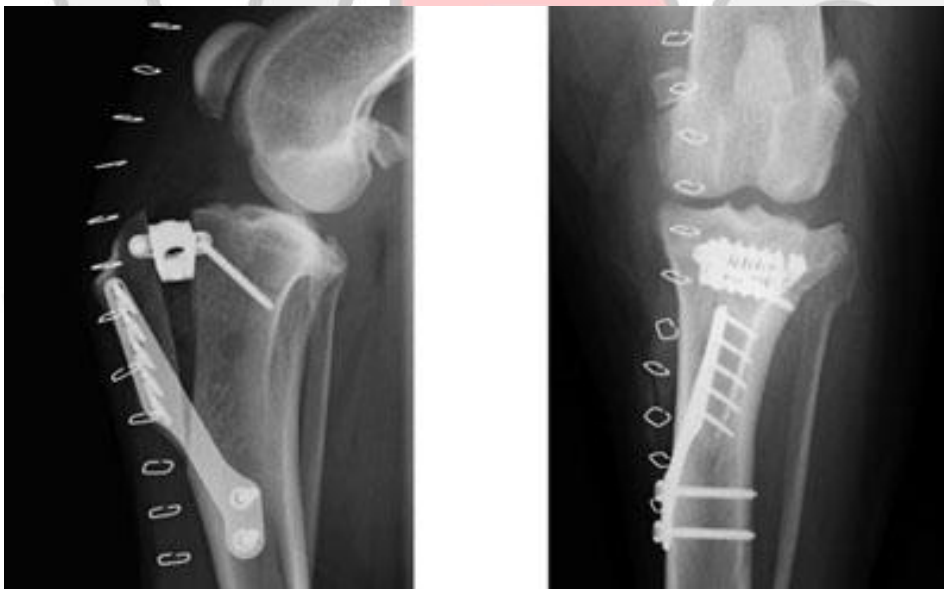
Stifle joint X-ray after having a TTA performed.
